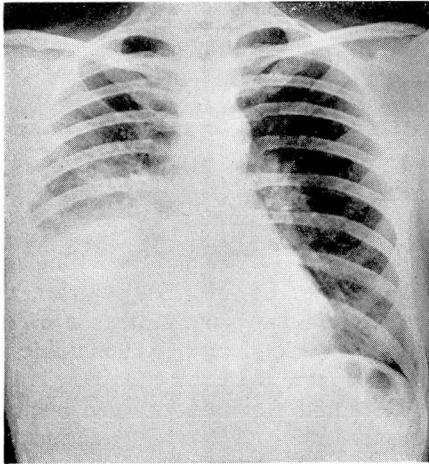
Case 3. Roentgenogram of chest.
